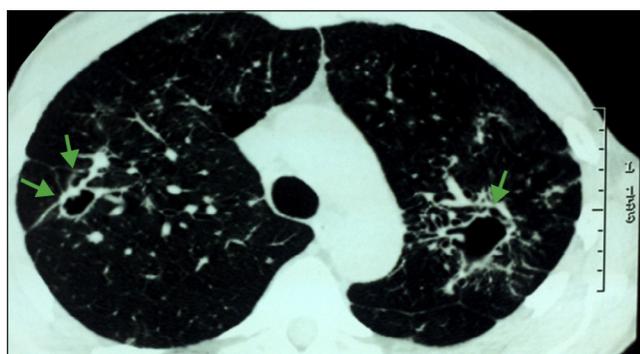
Chest high resolution CT scan, slice of 512 x 512 pixels, in a 55-year-old man, Caucasian, resident in the rural area and joint pain showing cavitations in both lungs, indicated by the arrows.
